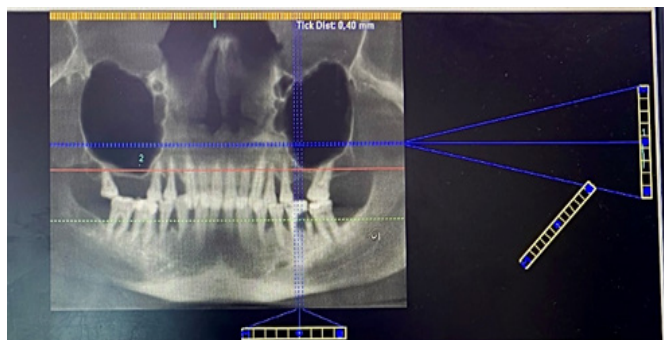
Preop cone beam computed tomography image
